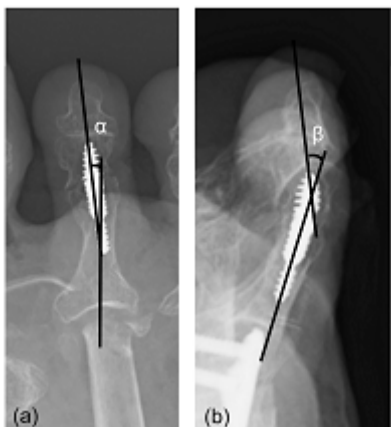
The evaluation of the alignment of PIP joint. No-weight-bearing anteroposterior (a) and lateral (b) radiographs. The α angle (a) and β angle (b) are defined as the angles between the long axes of the proximal phalanx and the middle phalanx on the anteroposterior and lateral radiographs, respectively.
